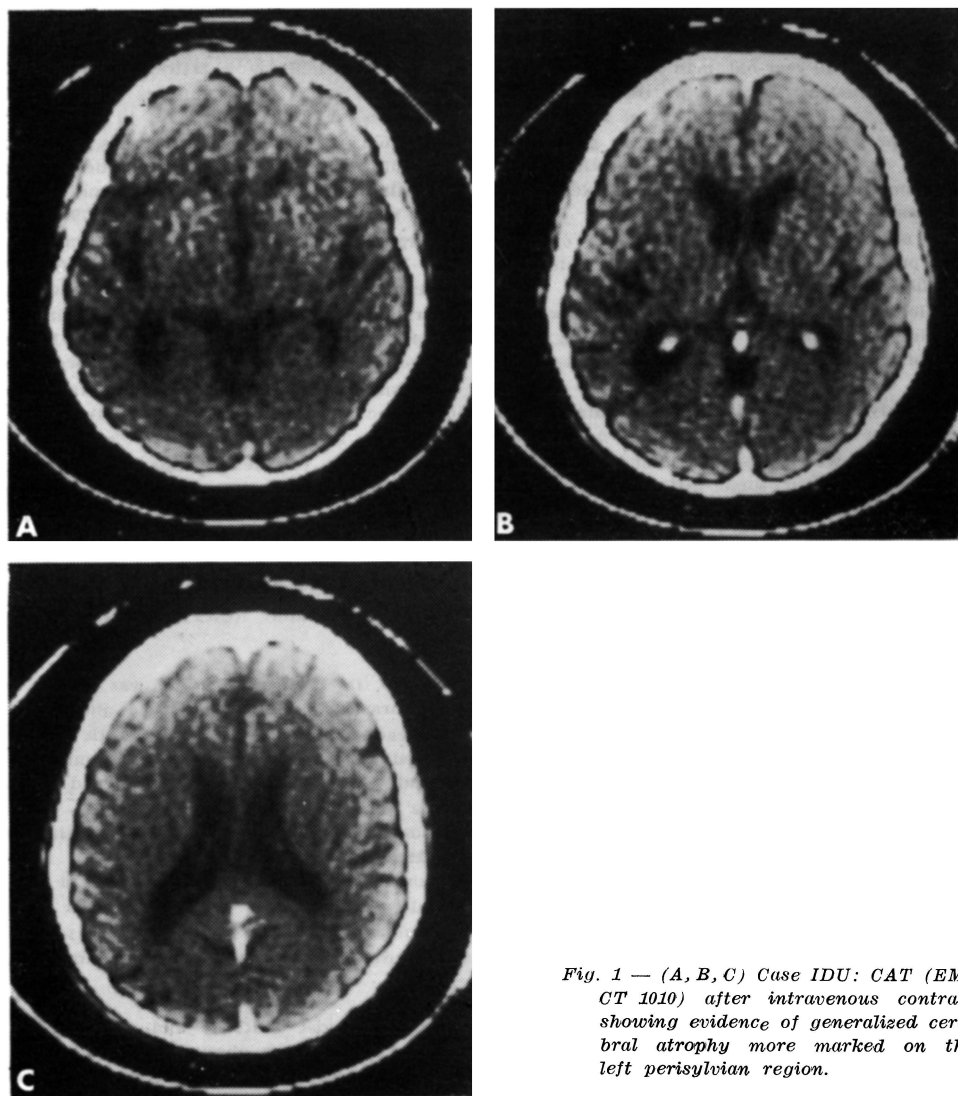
(A, B, C) Case IDU: CAT (EMI CT 1010) after intravenous contrast showing evidence of generalized cerebral atrophy more marked on the left perisylvian region.
